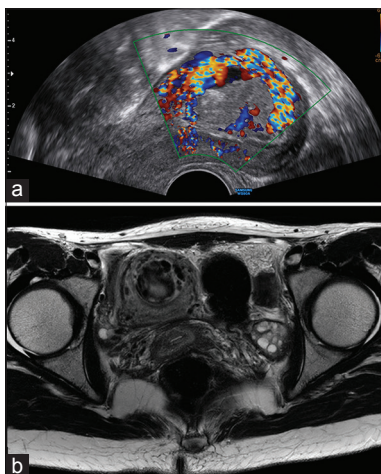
Representative images of arteriovenous malformation. (a) Visualization of the arteriovenous malformation by transvaginal ultrasonography with color Doppler. (b) Visualization with pelvic magnetic resonance imaging
